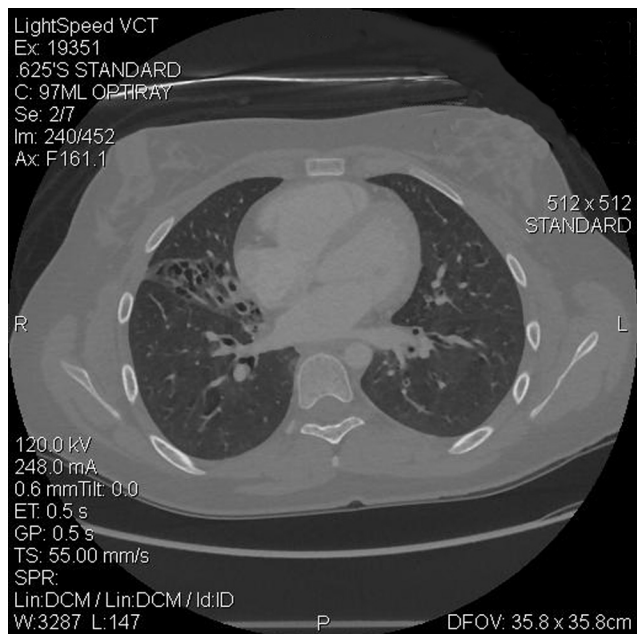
Computed tomography (CT) chest scan revealing extensive bronchiectasis in the right middle lobe.
